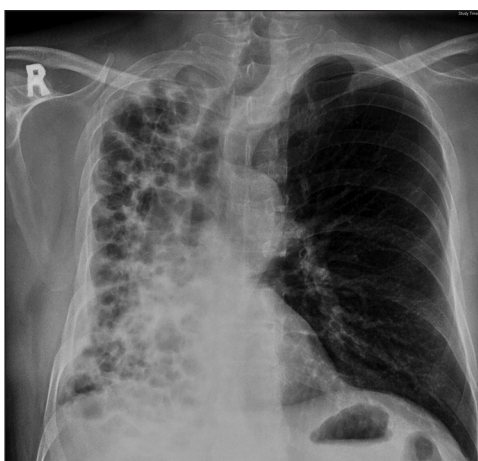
Preoperative chest X-ray showing bronchiectasis and fibrosis involving the right lung with the shift of mediastinum to the right
